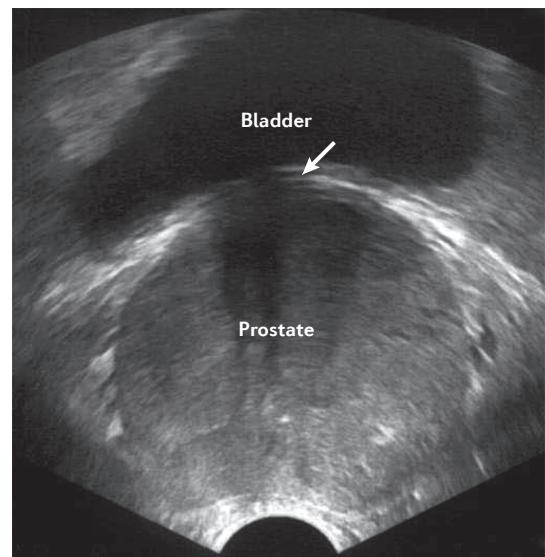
Transrectal ultrasonography. A sonographic image of an enlarged prostate using a transrectal probe. The prostate is evident below and adjacent to the bladder. The prostate is enlarged with the upper or proximal margins ‘bulging’ or ‘indenting’ into the bladder (arrow). This enlargement will lead to bladder outflow obstruction and subsequent lower urinary tract symptoms.
